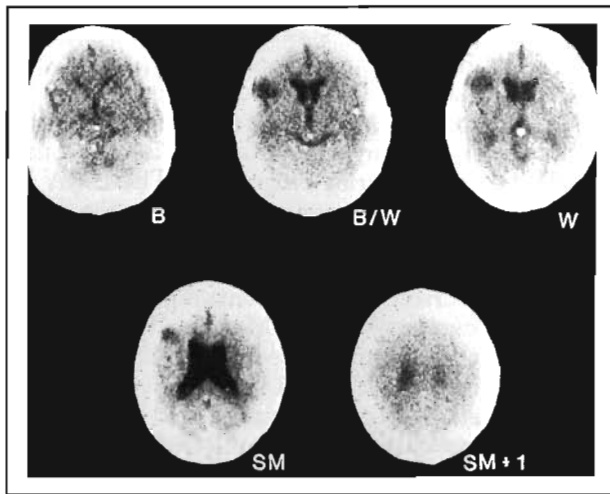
CT of TCM aphasia case with stuttering. Lesion is located in the pars opercularis part of Broca's area (slice of B/W) and in the lower third of the premotor area (slices W and SM). Patient 15, aged 42, 1 year postonset.
